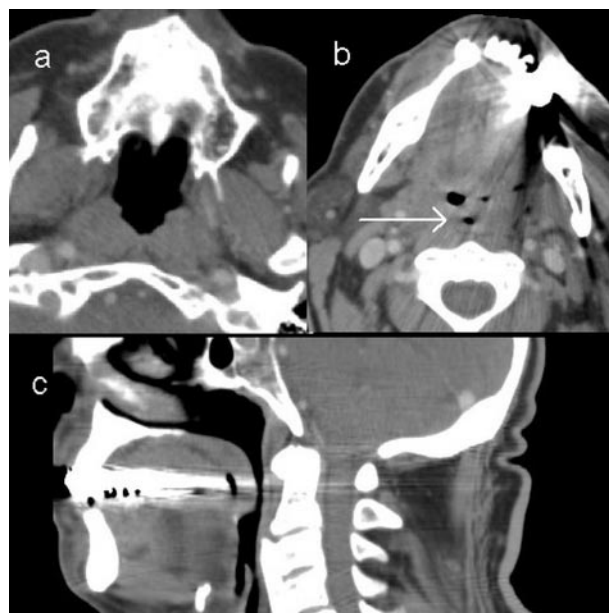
CT scans of a snoring person. *Top left, a:* Area at the hard palate level ( $7.26 \text{ cm}^2$ ). *Top right, b:* Area at the most narrow level ( $0.18 \text{ cm}^2$ ; indicated by the arrow). *Bottom, c:* Sagittal projection of the pharynx. The inspiratory pharyngeal narrowing ratio is 40.3.
